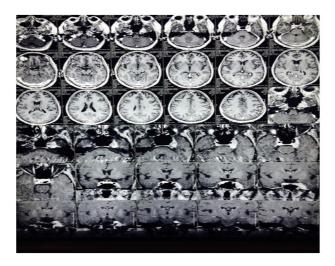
MRI report showing trigeminal schwannoma.
